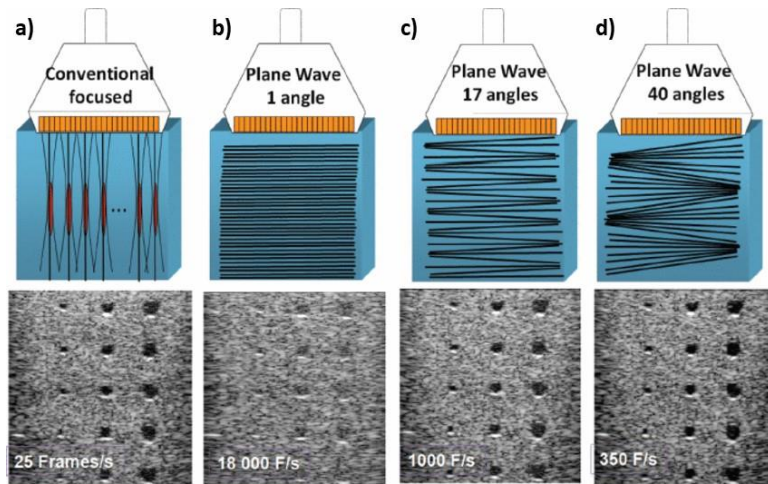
Conventional focused and ultrafast ultrasound imaging sequences for a typical medical imaging setup: (a) conventional focused imaging ( $\approx 25$  Hz), (b) plane-wave imaging ( $\approx 18$  kHz), (c) plane-wave compounding with 17 angles ( $\approx 1$  kHz), and (d) plane-wave compounding with 40 angles ( $\approx 350$  Hz). Image quality is improved with the number of sub-images compounded at the expense of the framerate. [figure reported from (Tanter and Fink 2014)]
